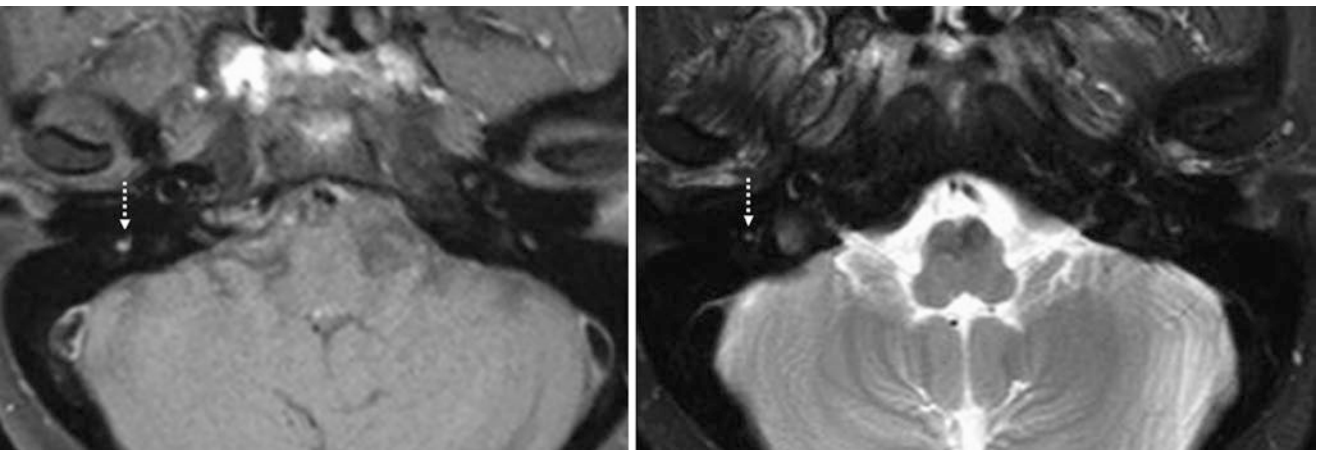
A 58-year-old patient with a negative 3 T MRI IAC protocol for dizziness. An axial postcontrast FS SET1WI (*left*) depicts mild enhancement of the right descending (mastoid) segment of CN7 (*dotted*
